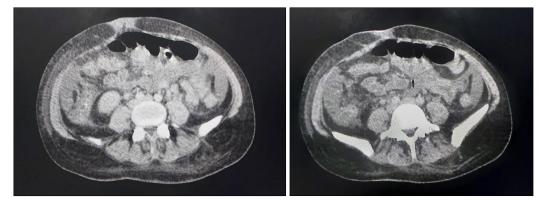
Abdominal CT-Scan images showing bowel wall thickening, submucosal oedema, infiltration of mesenteric fat
